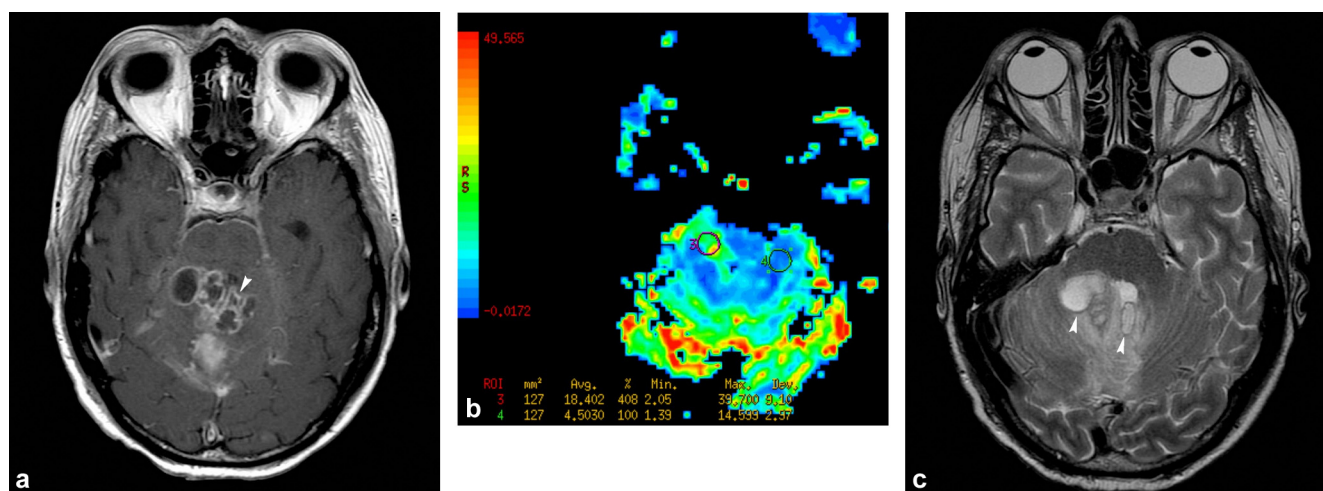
Cerebral MRI in patient 2: a: T1-weighted gradient echo axial image after IV of gadolinium chelate (TR/TE: 20/5 ms) shows a lesion in the vermis with a multiloculated appearance; b: perfusion-weighted image (cerebral blood volume mapping) shows an area of increased perfusion (region of interest shown in violet) with a blood flow four times greater than that of the contralateral healthy area; c: T2-weighted TSE axial image (TR/TE: 6280/94 ms) shows a multicystic appearance with a peripheral hypointense line (arrowheads).
